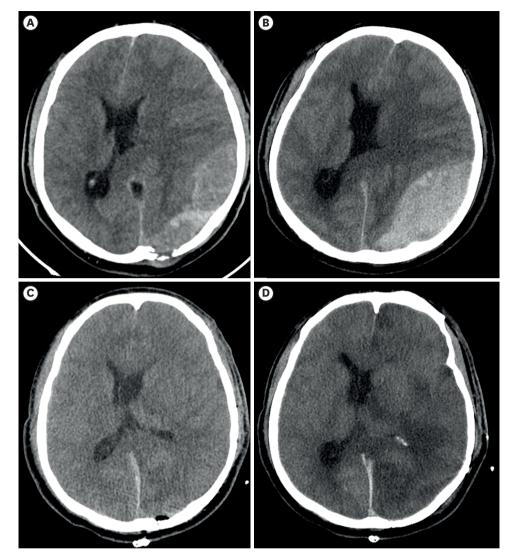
Serial brain CT scans.
